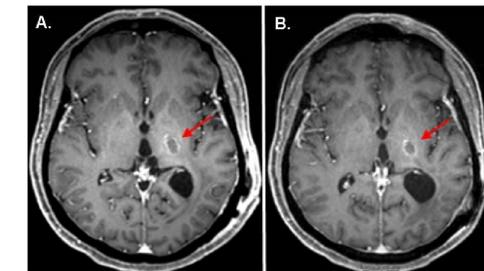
MRI demonstrating an unresectable lesion in the left thalamus progressing on bevacizumab at C1D0 (A) and after 10 cycles of TH-302 (340mg/m²) with bevacizumab (B).
